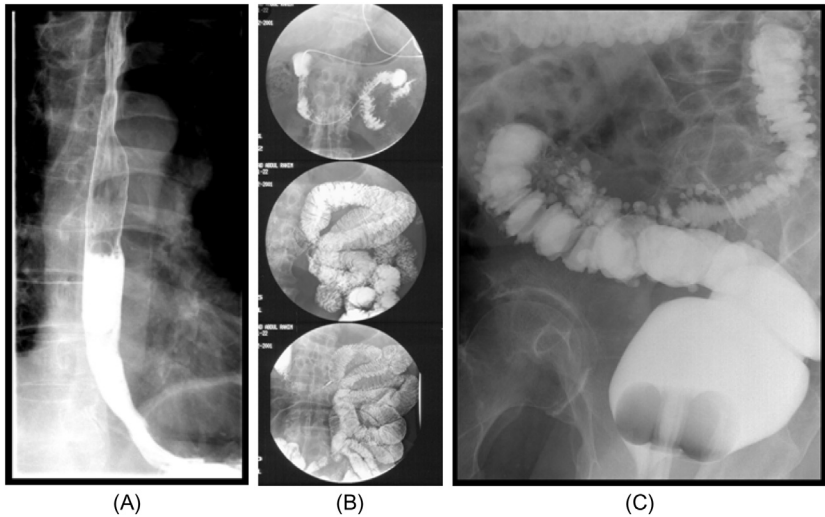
(A) High-speed fluoroscopy of the esophagus; (B) dynamic radiographic examination (fluoroscopy) of the small intestine (so-called Selling examination): Initially, the duodenum and the first jejunal loops become visible (middle up); middle center: after a few minutes, the loops of the jejunum are visible; middle bottom: the last loops of the ileum appear. (C) Exploration of the rectum/descending colon using a barium enema. All: Courtesy: Dr. K. Holzapfel, Klinikum rechts der Isar.
